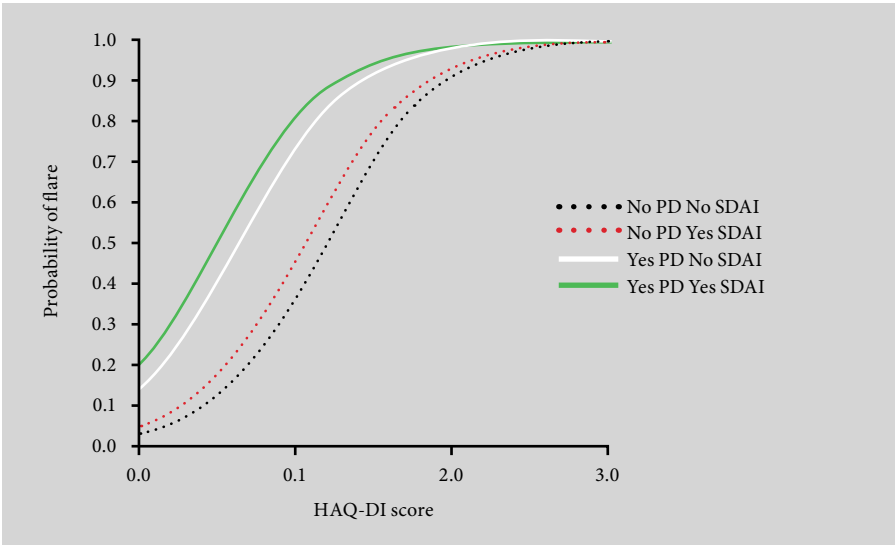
The probability of flare from the regression model that included power Doppler (PD), Health Assessment Questionnaire Disability Index (HAQ-DI) and Simplified Disease Activity Index (SDAI) remission. For all four lines, the probability of flare increases with increasing HAQ-DI score. The presence of PD (solid lines) gives an increased probability of flare compared with absence of PD (dotted lines), but the difference between being in SDAI remission (green and red lines) or not (white and black lines) is comparatively much smaller. Reproduced with permission from Saleem et al [37]©BMJ.
